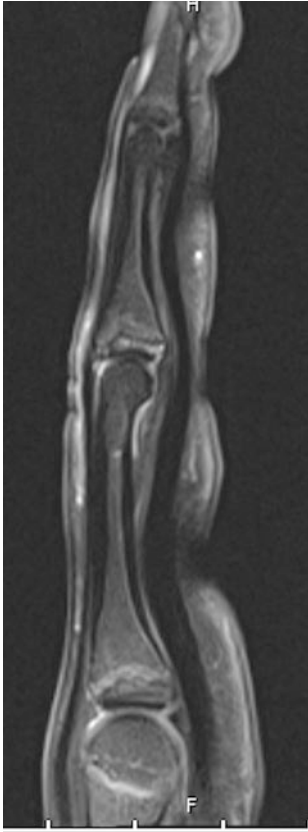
MRI with complete fusion after 4 months
